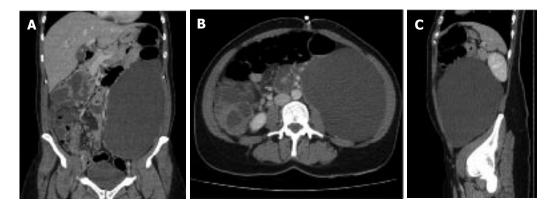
Computed tomography of the abdomen and pelvis showing a large-sized mesenteric cyst. A: Coronal plane-craniocadual diameter of 21.7 cm; B: Transverse plane - transverse diameter of 11.8 cm; C: Saqittal plane - antero-posterior diameter of 14 cm.
